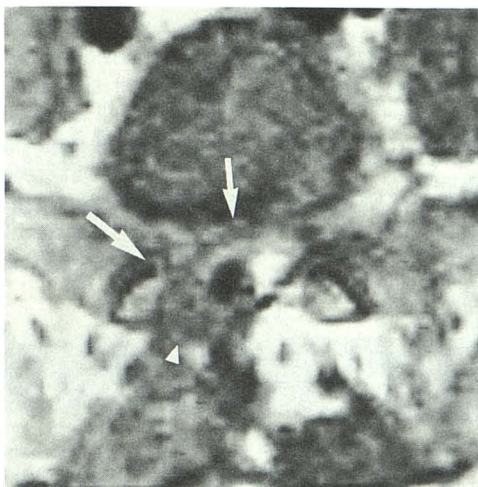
Scar with central disk herniation in 36-year-old man who had right L5–S1 discectomy 6 weeks earlier. A mildly hypointense extradural mass (arrows) compresses thecal sac on right and extends posteriorly into laminectomy site (arrowhead) on this axial T1-weighted image at low L5 level. The portion of this mass anterior to thecal sac was thought to represent an associated midline bulging disk. At surgery, dense scar tissue was identified, but deep to the scar in the midline the surgeon found a free central disk fragment.
